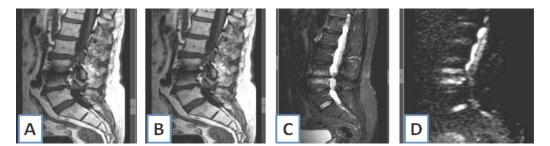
56 years old male presents with back pain. A: Sagittal T1show L3-4 endplate hypo signal intensity. B: Sagittal T2 show L3-4 endplate hyper signal intensity. C: Sagittal STIR shows L3-4 endplate hyper signal intensity. D: Sagittal DWI show L3-4 probable claw sign, final diagnosis was Modic 1 degenerative changes.
